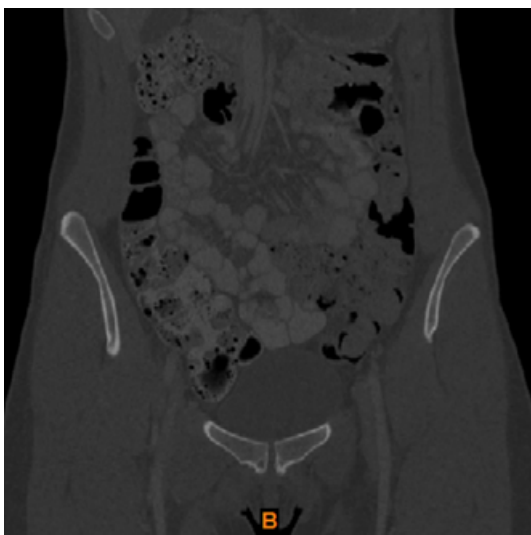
Image of a pelvic CT scan in the coronal view.
